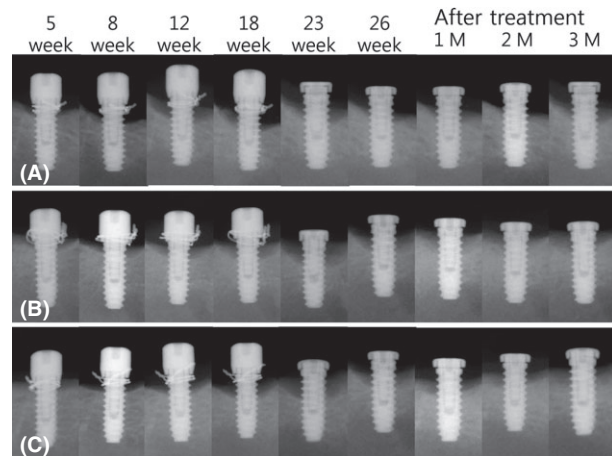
Representative radiographs showing crestal bone levels at weeks 5, 8, 12, 18, 23, and 26 of peri-implantitis defect induction, and at 4, 8, and 12 weeks following guided bone regeneration for turned (A), SA/HA (B), and SA (C) implants.
